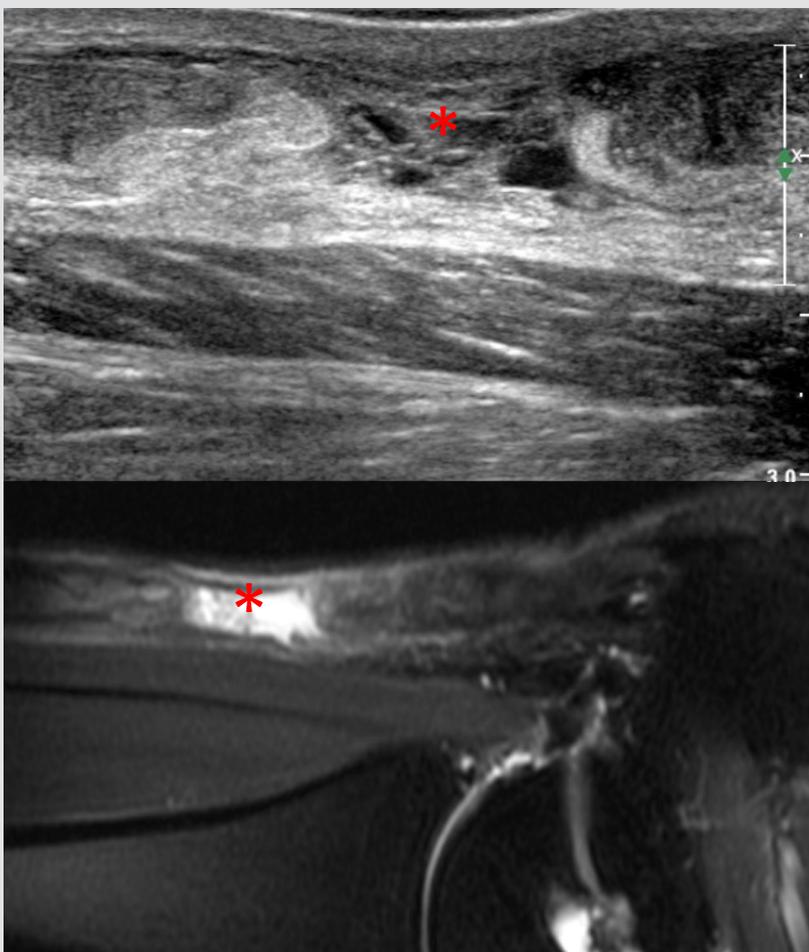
Full thickness Achilles tendon tear (*) on ultrasound in long axis (top image) and in sagittal plane on MRI (rotated to display in same orientation as ultrasound). Fluid and hemorrhage at sight of tear and proximal and distal tendon stumps visible.
